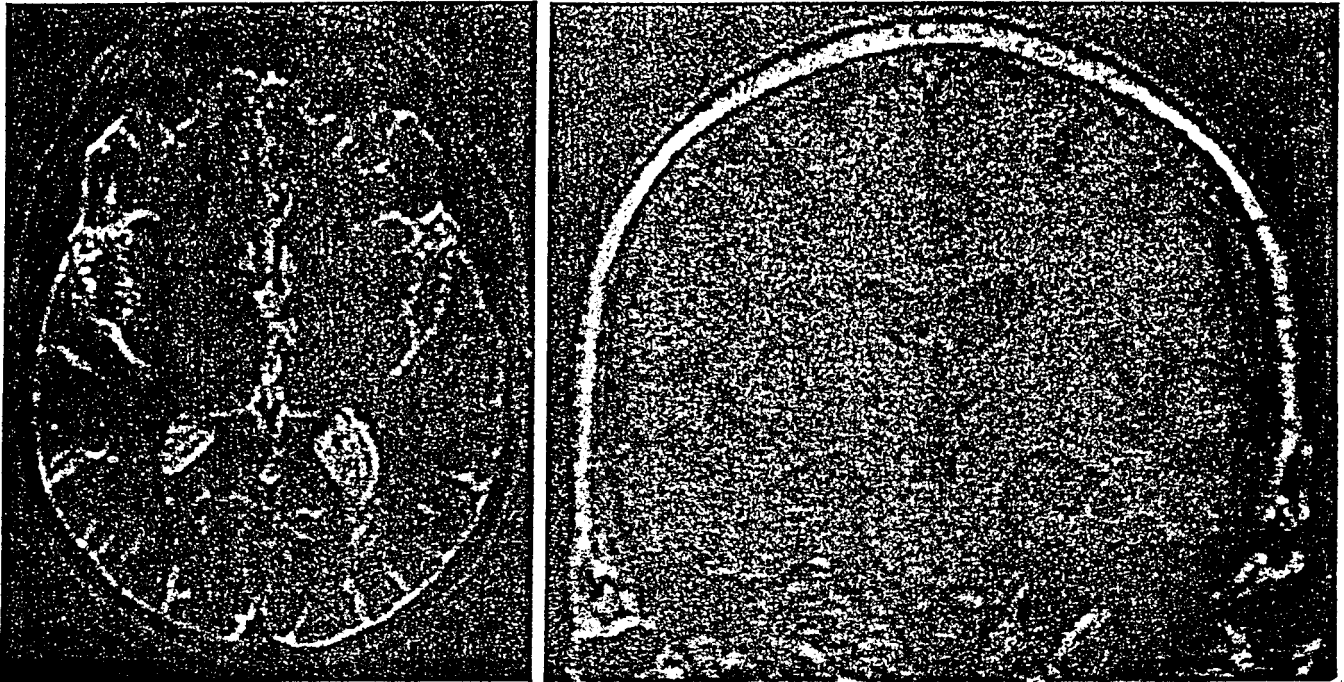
Axial T₂-weighted (left) and coronal fast low angle shot (FLASH) (right) magnetic resonance images showing a discrete left medial thalamic infarction. Images demonstrate the largest extent of the lesion.
